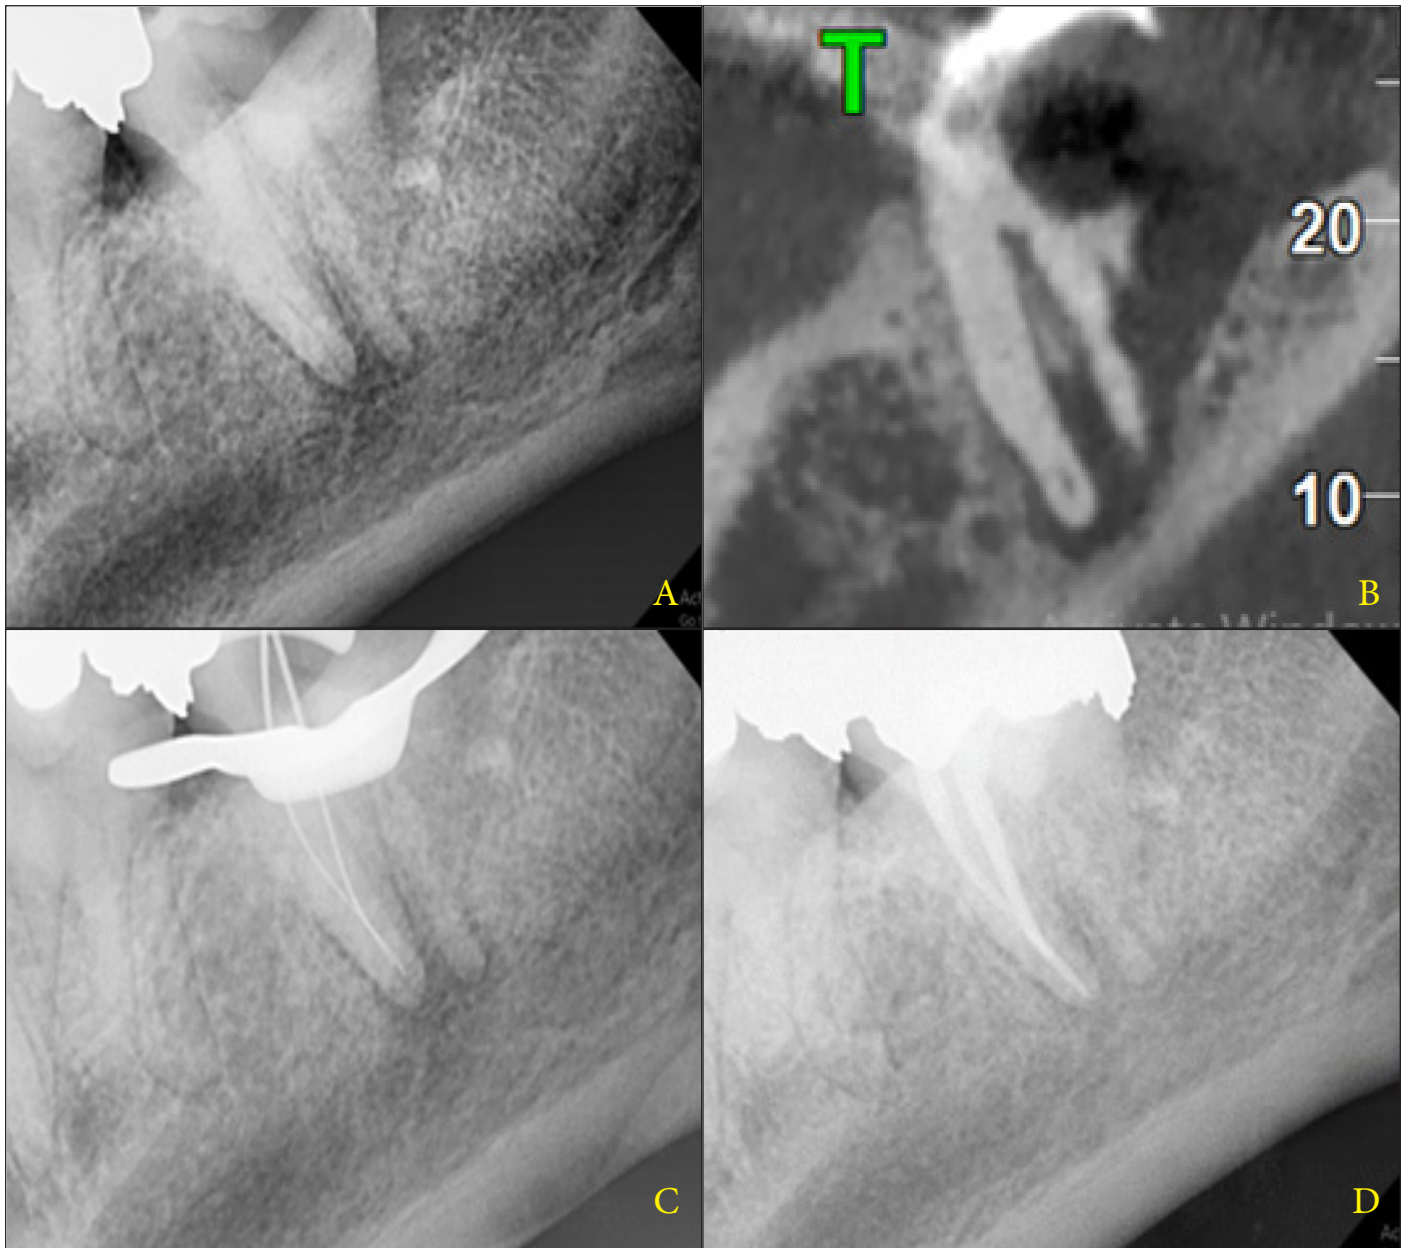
A) Periapical radiograph of tooth #18 showing extensive root resorption around the distal root of the tooth following extraction of tooth #17. B) Computed tomography images show that about half of the distal root of tooth #18 was affected by tooth #17. C) Initial file was placed in mesial canals. D) One year follow-up radiograph
